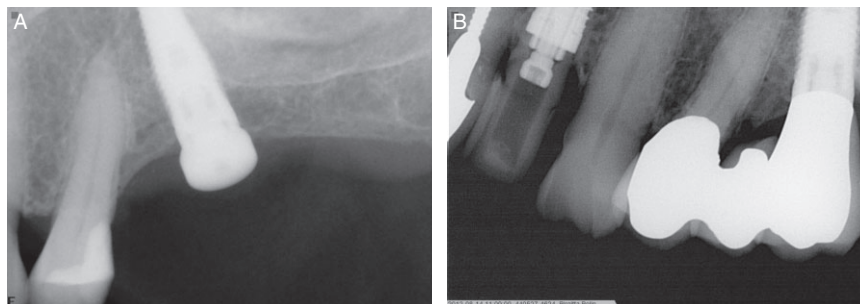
A, Radiograph taken after placement of an implant in upper second premolar region. B, Radiograph showing same site after 8 years of loading with an implant-tooth connected bridge.
